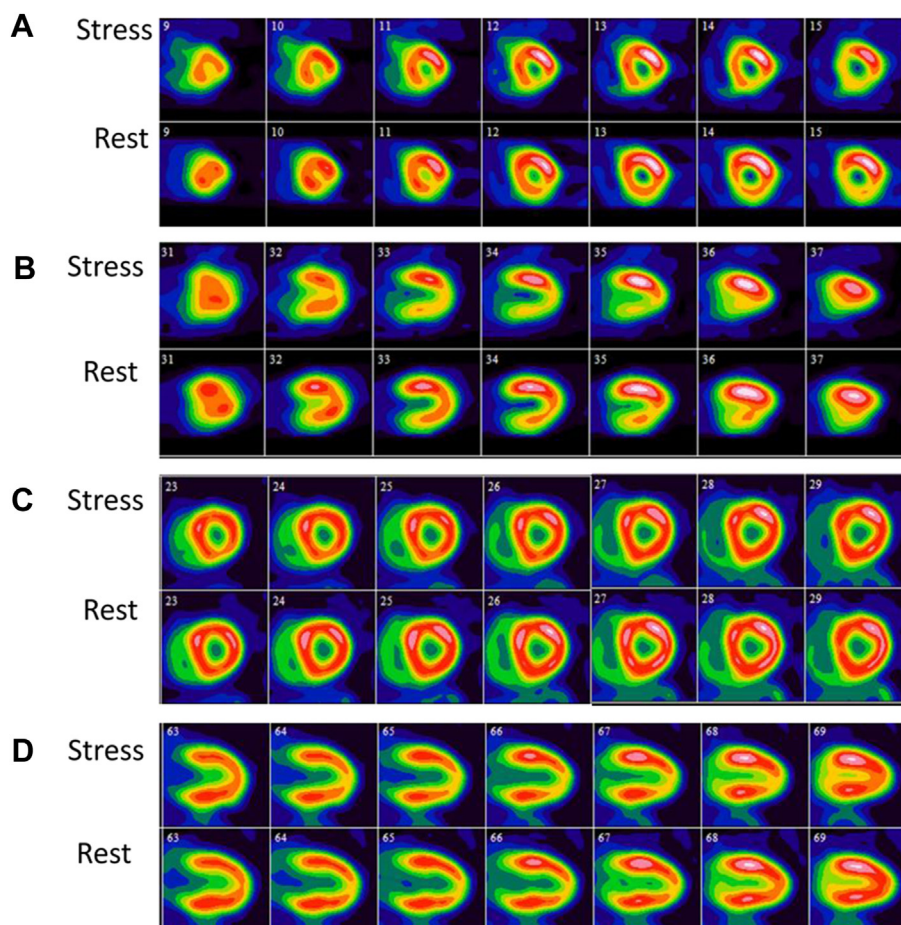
Stress thallium-201 single photon emission computed tomography (A, short axis, and B, vertical long axis images) in a 48-year-old woman who presented with atypical chest pain and a body mass index of 35. There is a mildly reversible perfusion defect in the inferior and inferolateral walls suggestive of mild ischemia in the right coronary artery territory. The patient was subsequently referred for rubidium-82 positron emission tomography (C, short axis, and D, vertical long axis images). Rest and stress perfusion images were normal and gated images showed normal wall motion. There was partial volume artifact at the apex of the left ventricle. She underwent coronary angiogram which showed mild coronary artery disease. Single photon emission computed tomography findings were believed to be artifact related to the patient's body habitus. She was given aspirin and rosuvastatin in addition to her antihypertensive medications. The patient started a graded exercise program and maintains an active lifestyle with good functional capacity.
